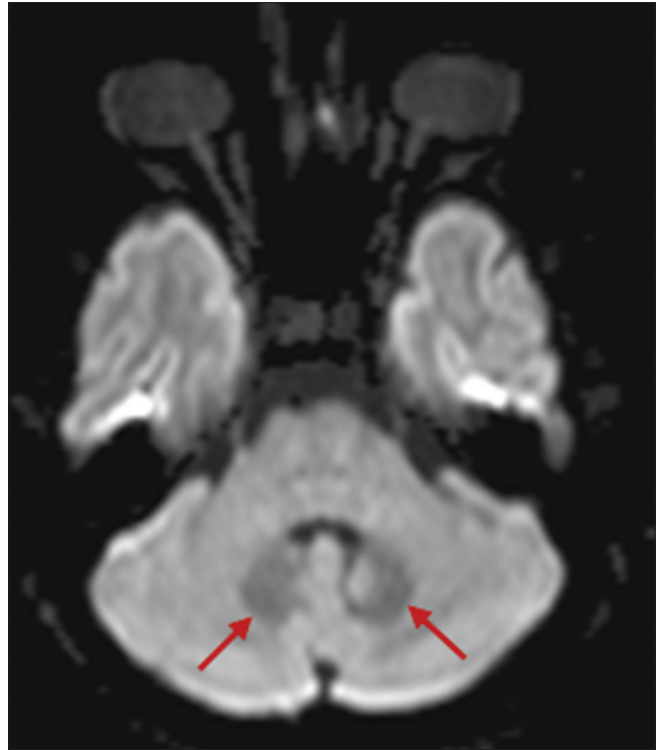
Axial DWI shows no restriction in both dentate nuclei of cerebellum
